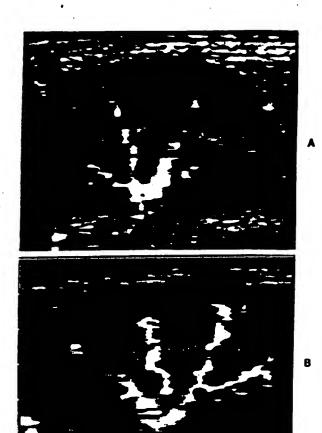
PFOB produces vascular enhancement. A, Baseline color Doppler image of a rabbit kidney. B, Shortly after intravenous administration of 2 ml/kg of PFOB, there is profound enhancement of the vascular signal, including visualization of the accurate ring and small cortical vessels. (From Coley BD, Mattrey RF, Roberts A, et al: The potential role of PFOB enhanced sonography of the kidney. Part II—Detection of partial infarction. Kidney International, in press, with permission.)
